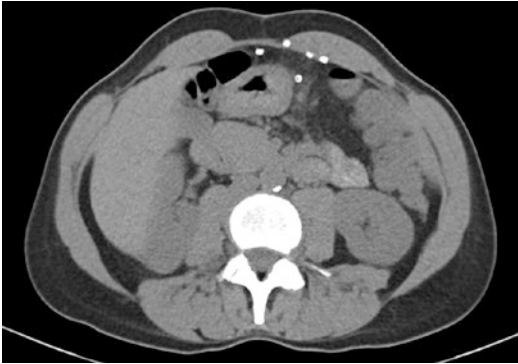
Ventral hernia repair with mesh and tacks. Metal tacks are best noted on CT scan. Note also the diastasis, difficulty in identifying the intraperitoneal mesh on CT, and the one tack that has fallen away from the repair
